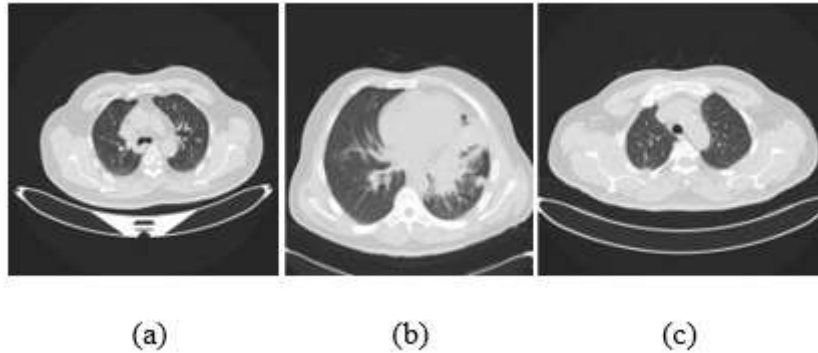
Sample CT Images From IQ-OTH/NCCD Dataset (A) Benign (B) Malignant (C) Normal Case
